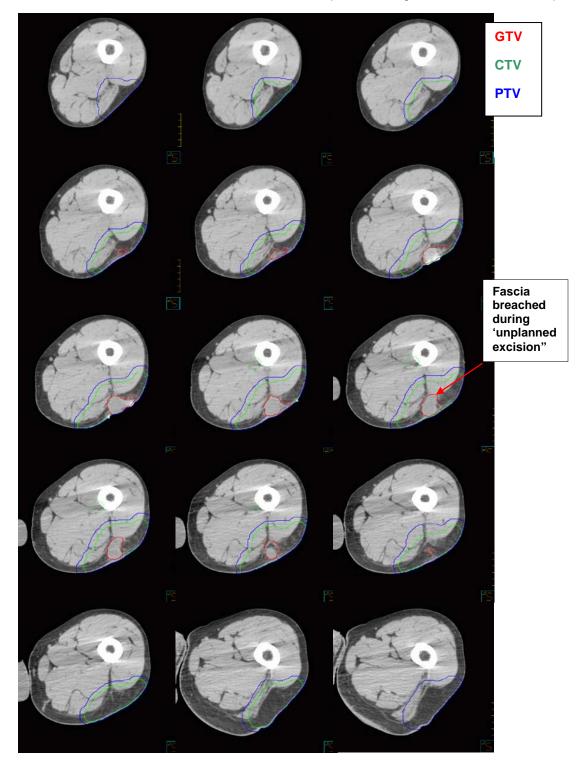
Example of GTV, CTV and PTV displayed in the sagittal view as well as an axial view of the disrupted fascia as a result of an unplanned excision with the corresponding planning CT target volumes.
